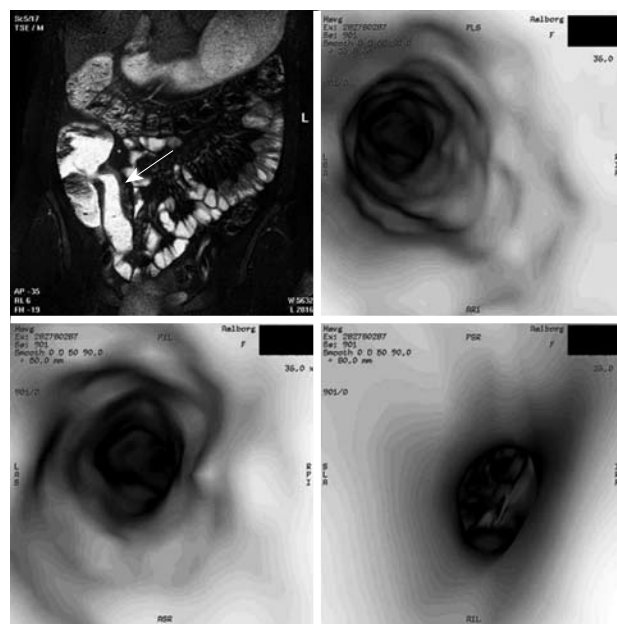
MRI of Crohn's disease. Virtual endoscopy views of the displayed diseased small bowel segment (arrow) shows mucosal nodularity, ileo-caecal narrowing and minor prestenotic dilatation. Modified from [36].
